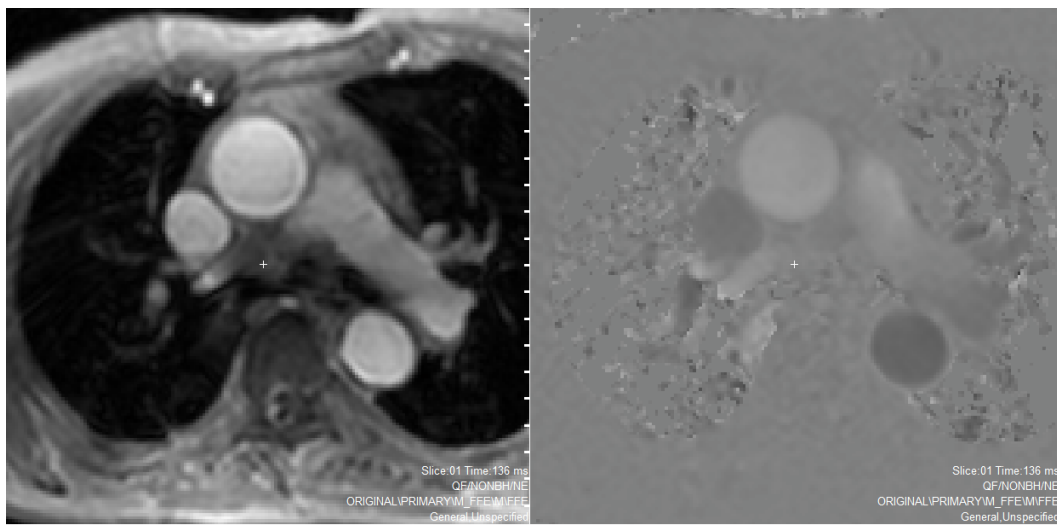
The magnitude image (left) and its corresponding phase image (right) from a PC-MRI scan. In the phase image, bright intensities represent high velocity in the gradient direction (perpendicular to the image plane) while dark intensities represent high velocity in the opposite direction.
